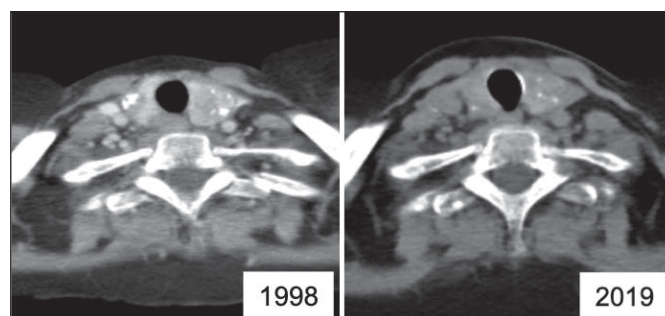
Cervical CT scan showing the left thyroid nodule (medullary thyroid cancer).
